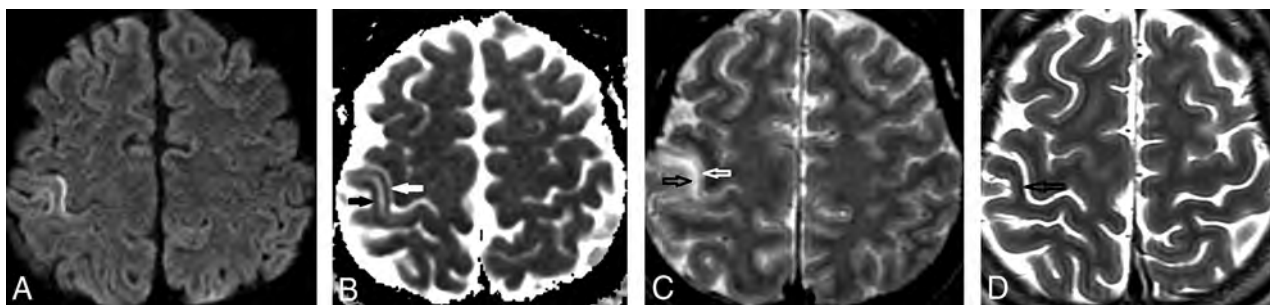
Axial MR imaging shows temporal evolution of an acute cortical lesion in a patient with MELAS presenting with an acute stroke-like episode with left upper limb sensory loss. A, DWI ($b = 1000$) image from the day after symptom onset shows hyperintense intracortical signal in the middle-third of the right postcentral gyrus (hand/arm region of the primary somatosensory cortex). B, ADC image shows corresponding hypointense intracortical signal in keeping with diffusion restriction (white and black arrows). C, T2-weighted spin-echo image shows T2 hyperintensity in the deeper cortical layers and juxtacortical white matter (black arrow), with sparing of the superficial cortex (white arrow). D, Progress T2-weighted spin-echo image obtained 3 weeks later shows focal intracortical hypointense signal (black arrow) and mild volume loss, in keeping with pseudolaminar necrosis (black toenail sign).
